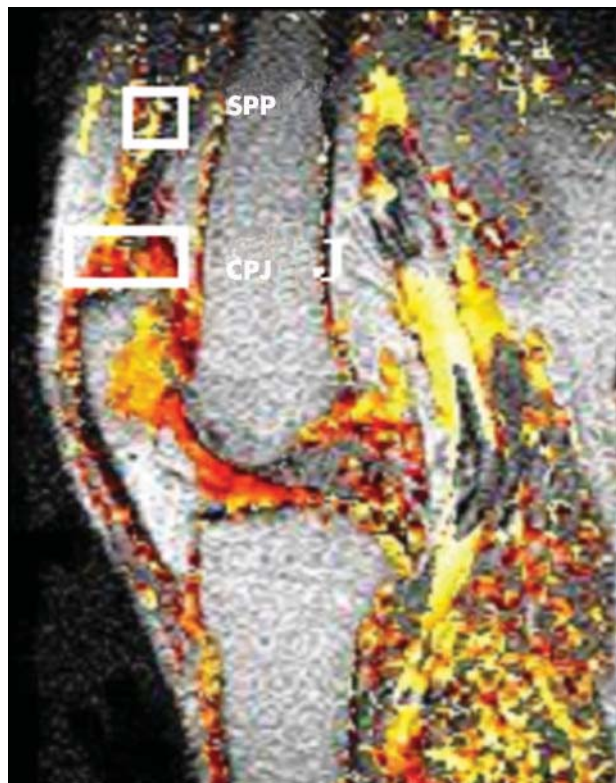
Conventional MR image acquired from the knee with superimposed colour data showing values of the IRE—pixels shown in yellow represent high IRE values while those in red show relatively lower values. Data were analysed in two regions of interest represented by white rectangles and located adjacent to the CPJ and the proximal SPP.
